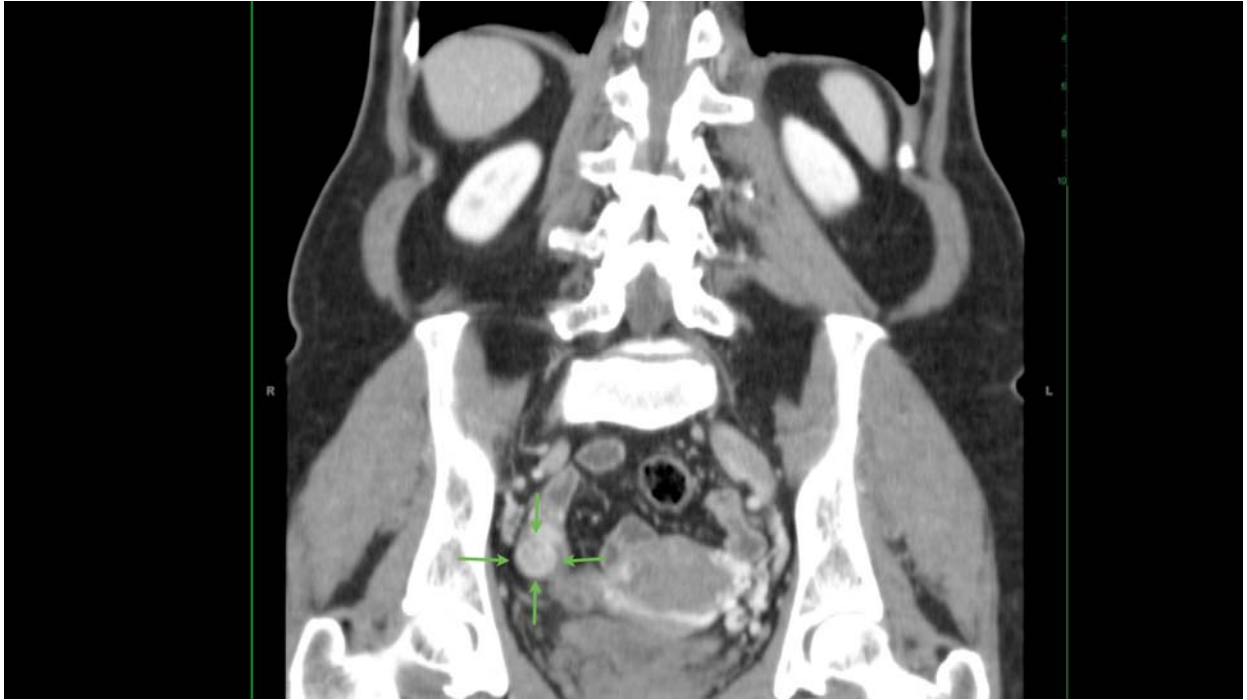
Coronal CT image from the patient's original contrast enhanced CT examination following an adrenal lesion protocol. The solid ovarian mass seen on endovaginal ultrasound examination corresponds to an enhancing mass in the right ovary, measuring 1.6 cm in transverse dimension, indicated by the green arrows.
